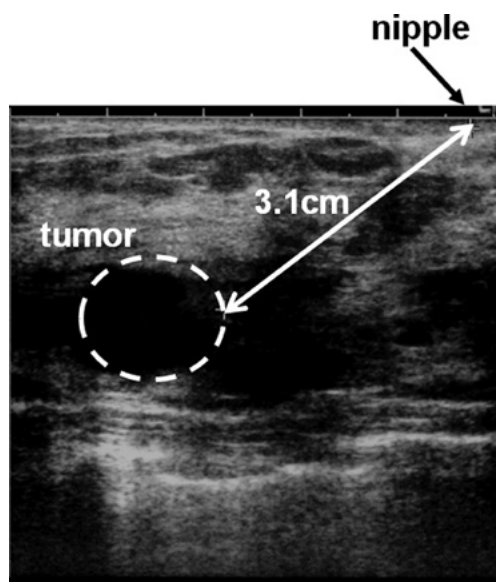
Distance from the nipple to the nearest tumor edge was measured using ultrasonography. In this case, the distance from the nipple to the nearest tumor edge was 3.1 cm.
